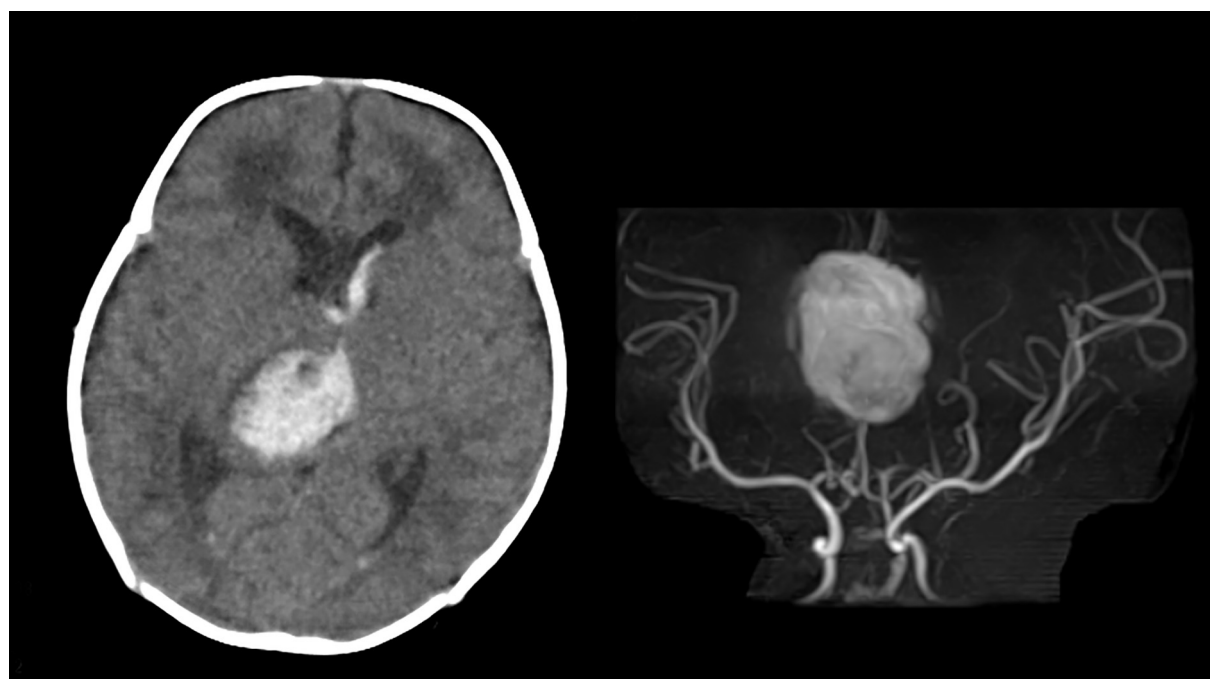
Head MRI T2-weighted imaging and MRA imaging of patient 1. *left*: Her head CT revealed right thalamic hemorrhage and intraventricular rupture. *right*: Her head MRA did not show obvious rupture of artery.
